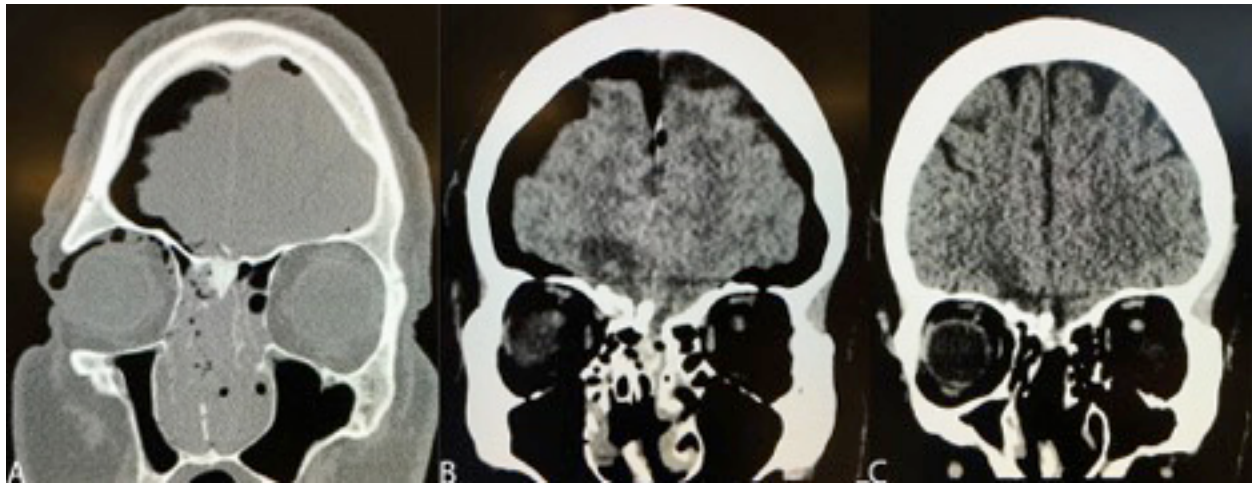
A. Maxillofacial computed tomography from outside facility demonstrating ethmoid, nasal, and cribriform fractures with pneumocephalus, with B. progression over the initial 24 hours following injury, and C. resolution of pneumocephalus at one month.
